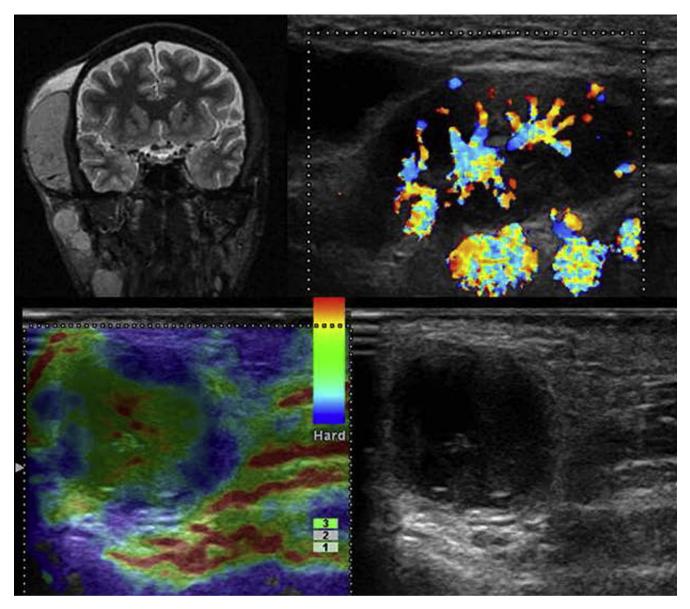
Right laterocervical neoplastic adenopathies: MRI, Color Doppler and USE appearance (note the mixt elasticity pattern within afflicted lymphnodes: soft cores with stiff periphery)
